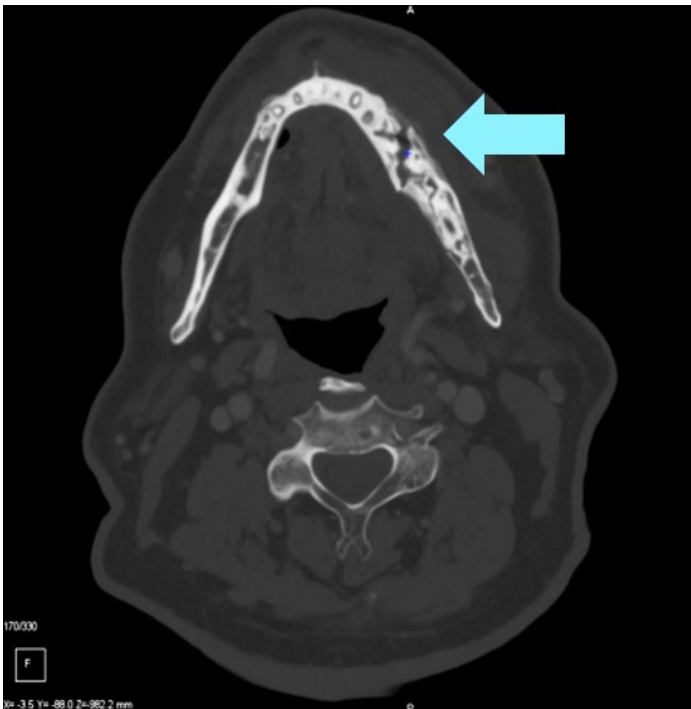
CT scan slice showing osteolysis of the left mandibular ramus caused by the solitary plasmacytoma.
